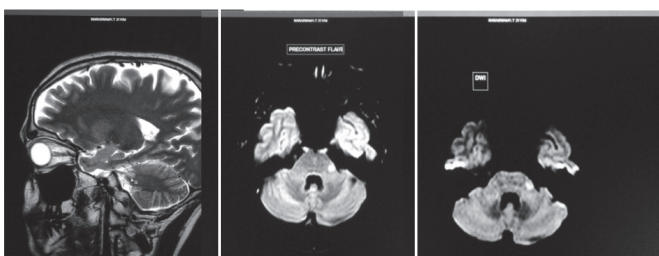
7&8: MRI Brain shows hyperintensities at left lateral part of pons at the origin of the trigeminal nerve on pre contrast T2 sagittal view, pre contrast FLAIR and pre contrast DWI sequences respectively.
